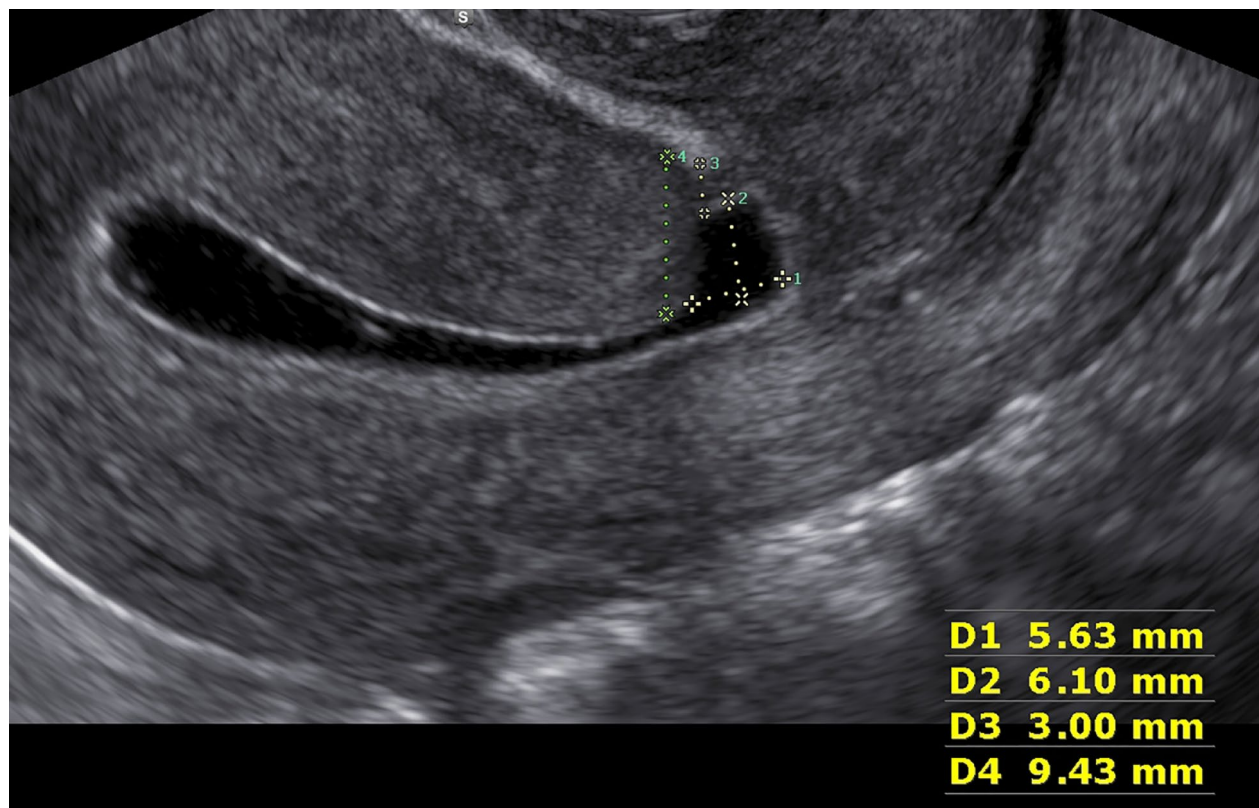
Ultrasonographic view of CSD measurements: (1) width of CSD, (2) Length of CSD, (3) Residual myometrium thickness (RMT), (4) Adjacent myometrium thickness (AMT).
